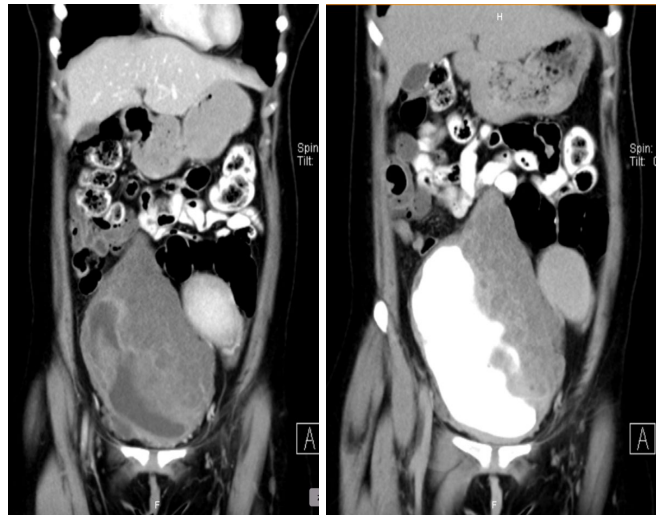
Delayed phase coronal view of CT scan showed huge bladder mass occupying abdomen with Irregular bladder mucosa of bladder.
